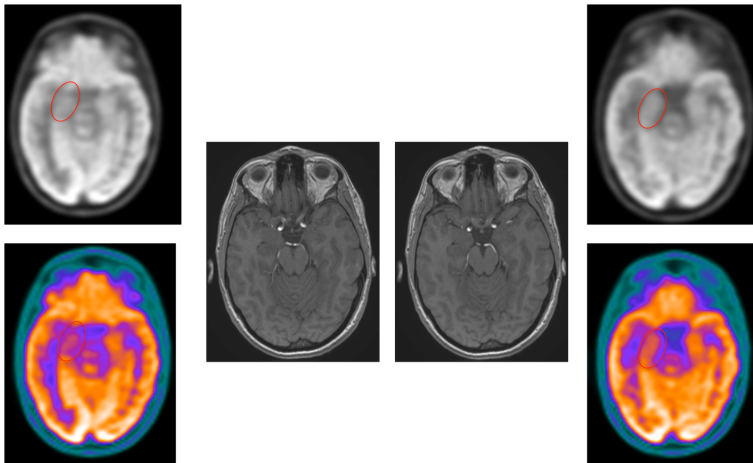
An example of a patient who is MRI-negative but PET-positive (on the left) and another patient who is MRI-negative and PET-negative (on the right). The red circle highlights the area of hypometabolism, which is clearly visible on the PET images of the PET-positive patient (on the left) but absent in the PET-negative patient (on the right).
